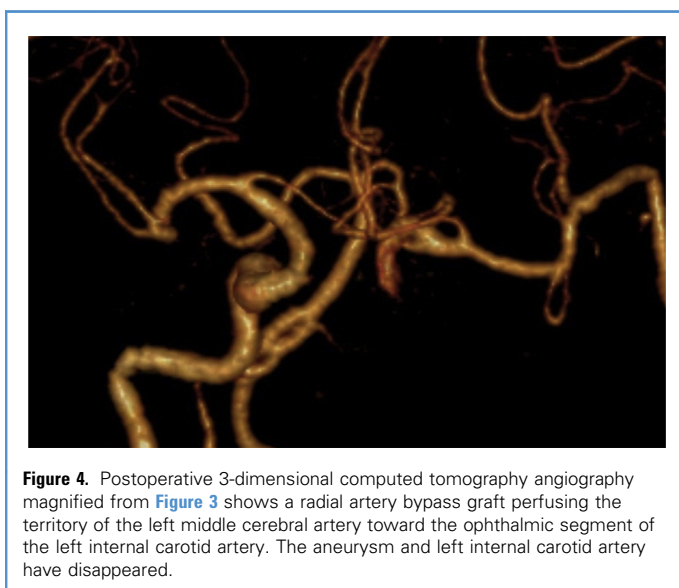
Postoperative 3-dimensional computed tomography angiography magnified from Figure 3 shows a radial artery bypass graft perfusing the territory of the left middle cerebral artery toward the ophthalmic segment of the left internal carotid artery. The aneurysm and left internal carotid artery have disappeared.
